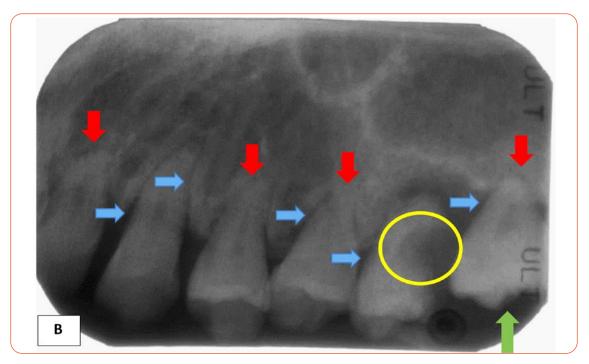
Periapical radiography of the upper left maxilla i.e. premolar and molar, indicating thick lamina (blue arrows), short roots (red arrows), microdontia (i.e., small tooth) (green arrow) and a carious lesion with periapical radiolucency (yellow circle).
